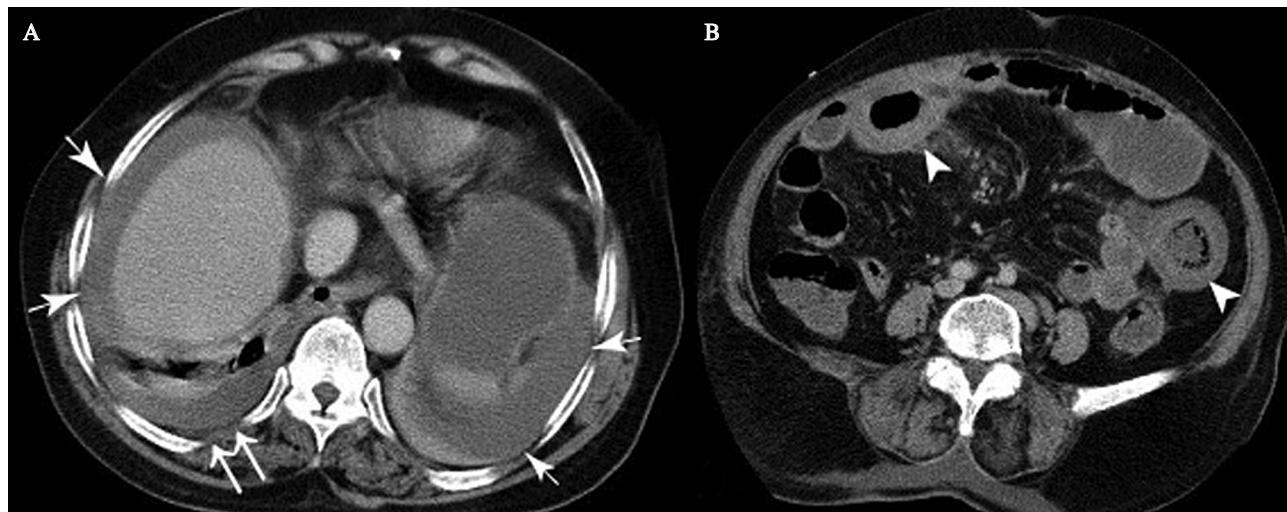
A 64-year-old female patient; abdominal CT imaging; (A) there is fluid in the right hemithorax (double arrow) together with intraabdominal free fluid around the liver-spleen (arrows) on the upper sections; (B) symmetrical and homogenous wall thickening in different jejunal segments on the lower sections (arrow heads).
